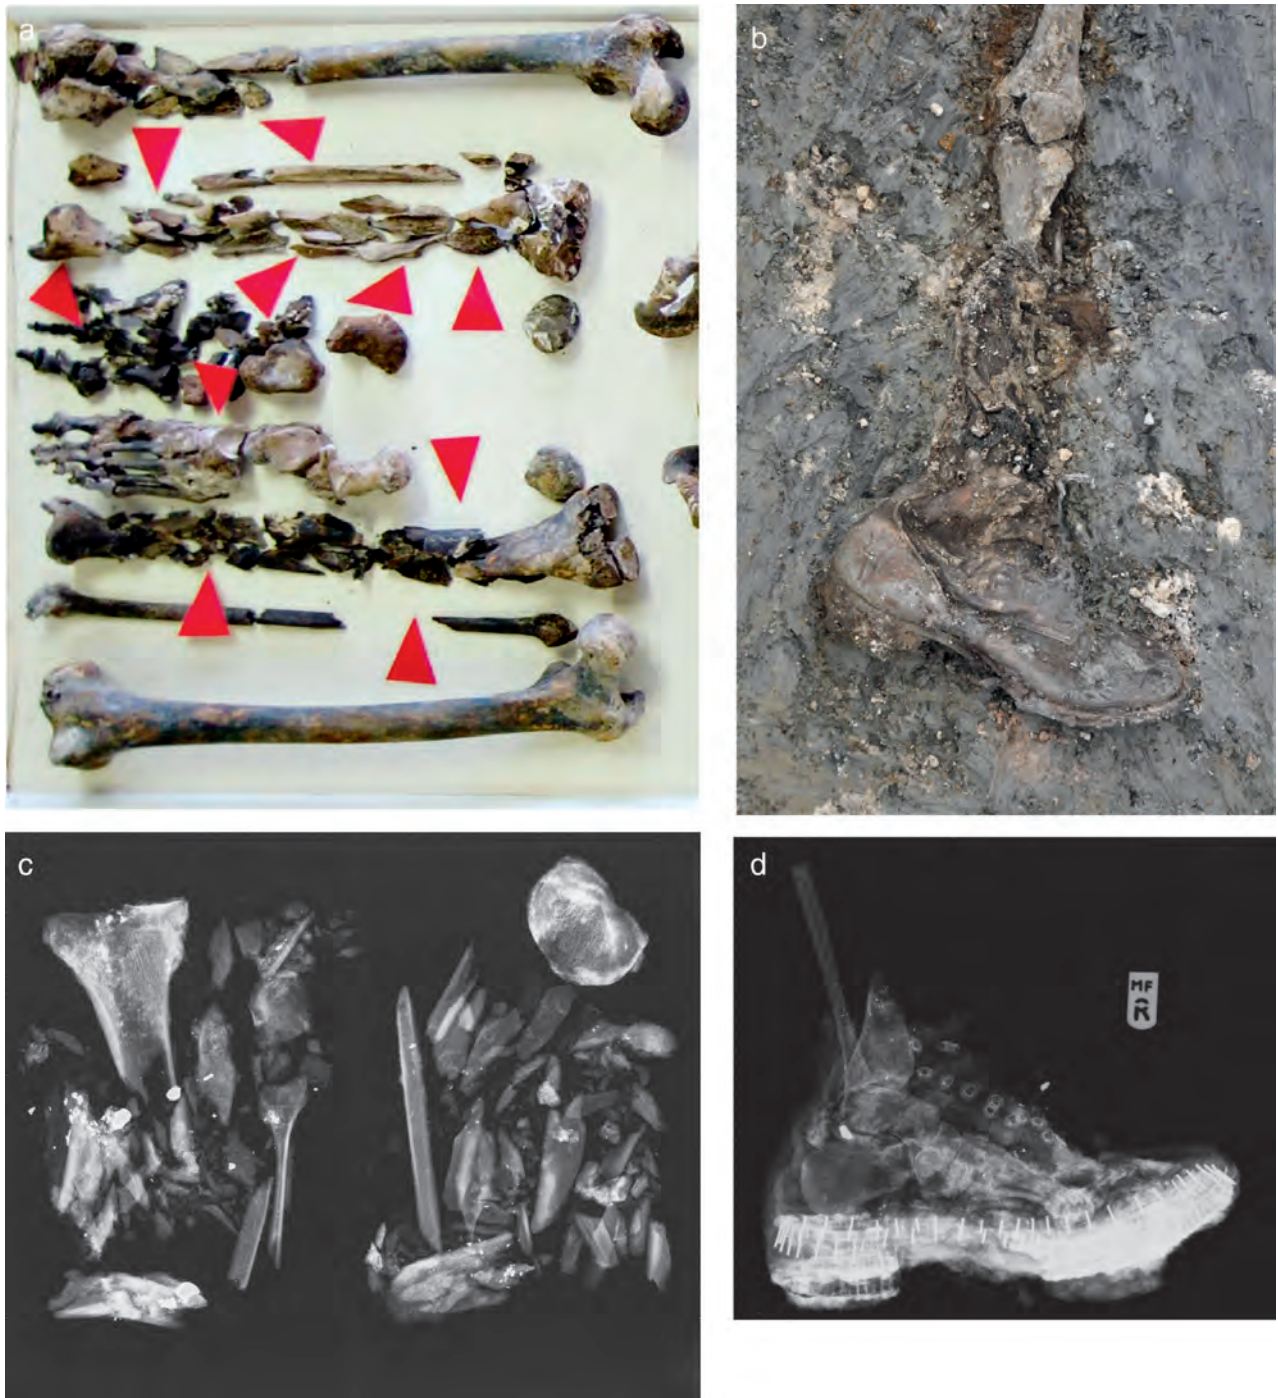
3089B: Bilateral partial limb amputation observed as mass comminution of right and left tibiae and fibulae, and right femur and foot bones; a) laboratory, b) in situ, c) radiographic image, d) radiographic image
